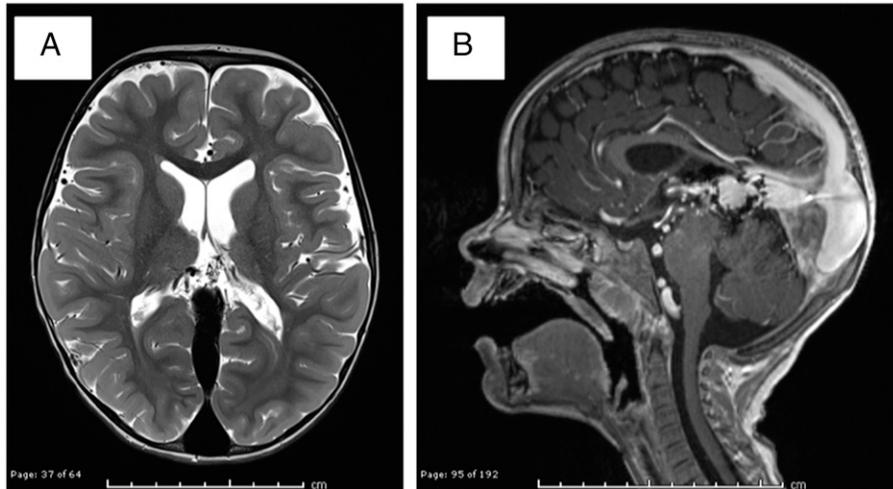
Magnetic resonance imaging (MRI) scan at follow-up. Axial and sagittal T1 MRI scans at 30 months of age. A. Stable size of vein of Galen malformation (VOGM). There is interval development of the brain with resolution of previously prominent extra-axial spaces. B. Susceptibility artifact from endovascular coils in the VOGM with little residual flow.
